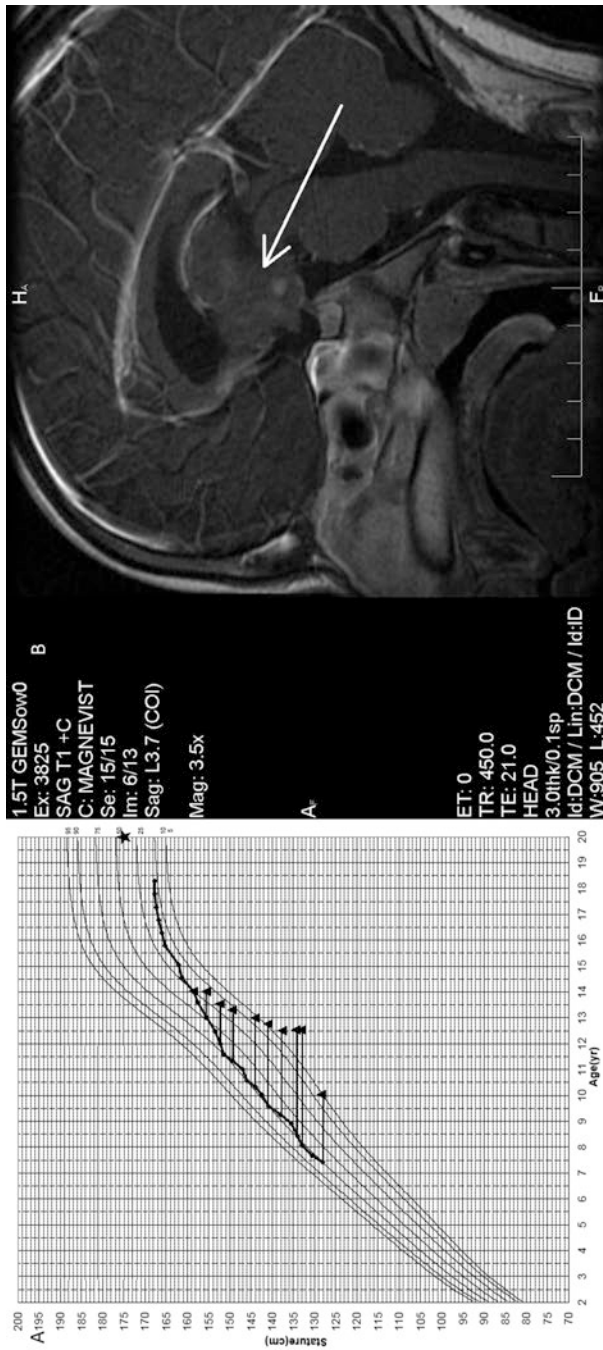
This patient presented at age 7.3 years with a 3-month history of pubic hair. He had no growth acceleration, axillary hair, apocrine body odor, or acne. He had no history of headache or vision disturbances. He had pervasive developmental delay with autistic features. His height was on the 75th percentile, and his midparental height was at the 45th percentile. (Panel a) His physical examination was remarkable for Tanner stage 3 pubic hair and testicular volumes of 10 mL bilaterally. His bone age was advanced to 10 years. Baseline laboratory studies included a serum total testosterone concentration of 56 ng/dL, LH of 1.9 μ U/mL and FSH of 0.8 μ U/mL. His 17-hydroxyprogesterone level was 262 ng/dL. An ultrasensitive LH concentration was elevated into the pubertal range (1.3 μ U/mL, normal for prepubertal males 0.20–0.3). An ACTH stimulation test was normal, excluding congenital adrenal hyperplasia. A magnetic resonance imaging scan of the brain revealed a poorly-defined hypothalamic mass with increased T2 signal and contrast enhancement with mild hydrocephalus, consistent with a low-grade astrocytoma. (Panel b) Additional tests of pituitary function were normal. Treatment with depot leuprolide acetate was initiated. After advancing during the first 6 months of treatment, his bone age stabilized and his pubertal maturation did not progress. Treatment was continued until age 12.0. At age 15.5 he had tumor growth and received proton beam irradiation. He was later diagnosed with hypogonadotropic hypogonadism and central hypothyroidism (Triangles represent bone age; star indicates midparental height)
